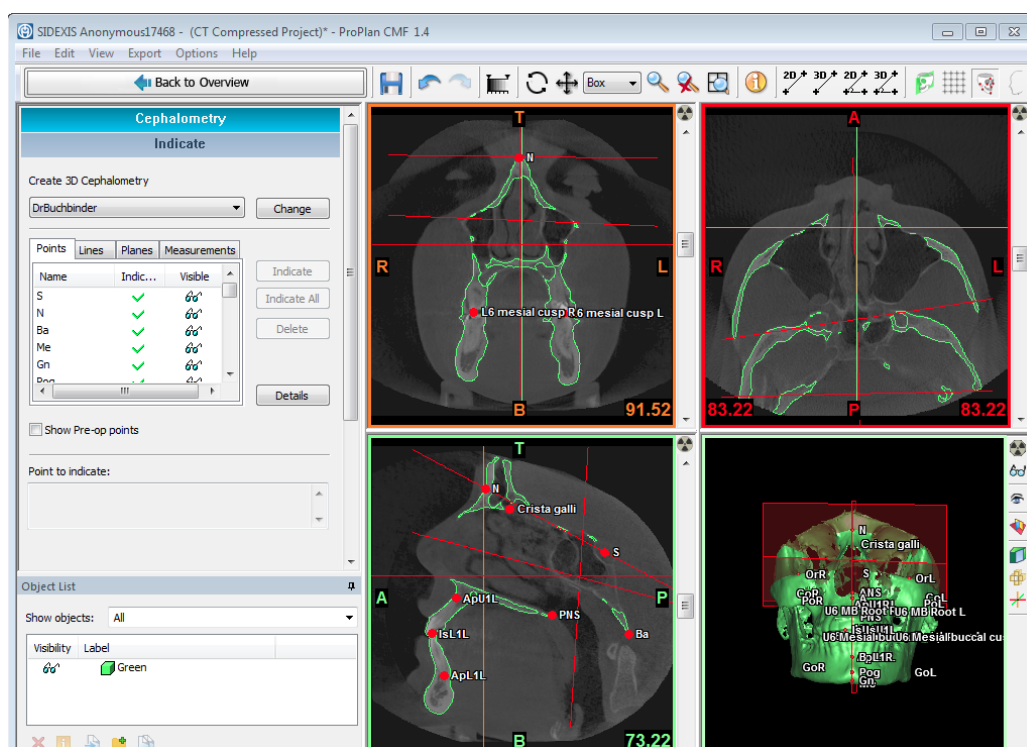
A screenshot of ProPlan CMF, demonstrating the multi-planar views and 3D model of a CBCT scan, including the landmarks identified. Reproduced with permission from Materialise.
